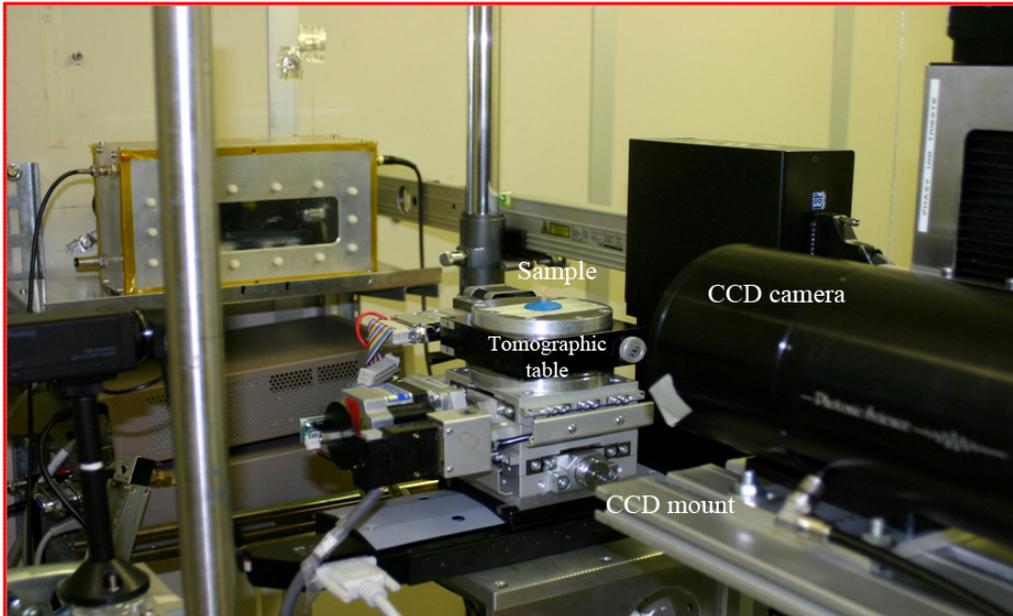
Microcomputed tomography system at SYRMEP beamline
